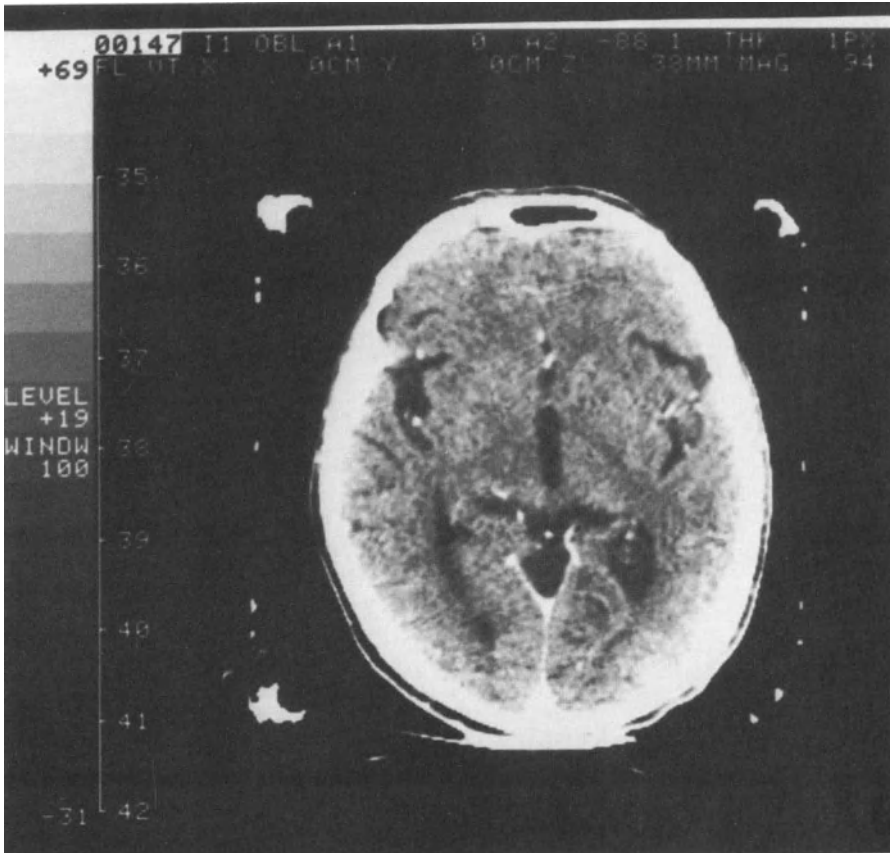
Reformatted horizontal CT image through the anterior and posterior commissures.
